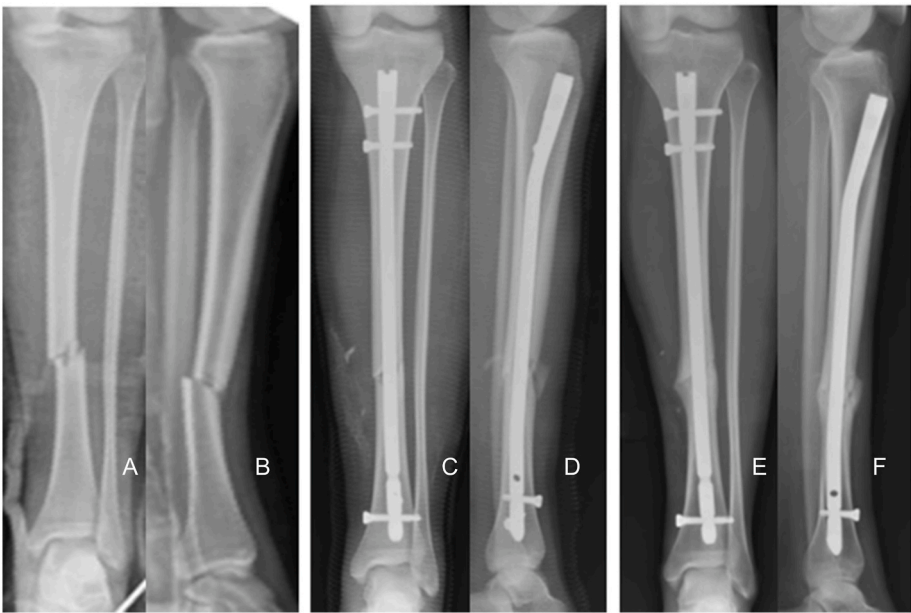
AB: AP – L radiographs of type A (OTA/AO)fracture. CD: Immediate postoperative AP and L radiographs showing the use of two distal locking screws in biplanar configuration (anteroposterior + mediolateral). EF: AP and L radiographs at six postoperative months showing bone healing.
